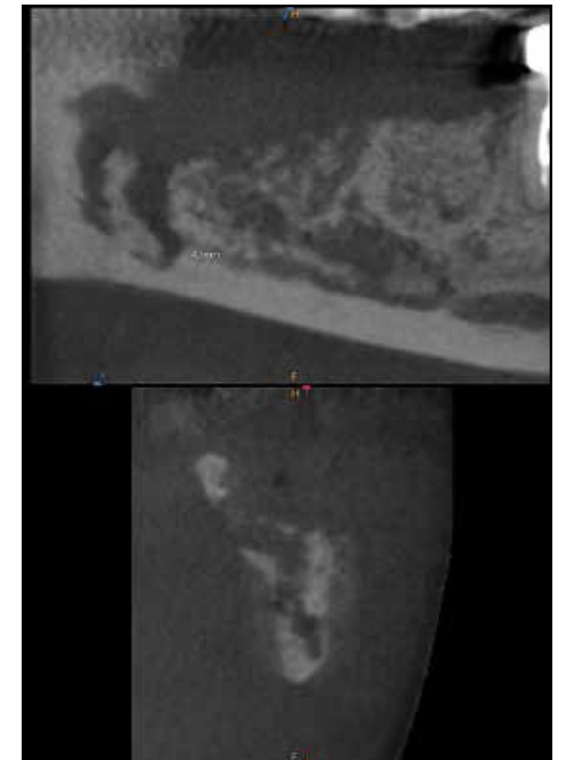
Dramatic infection-related osteolytic changes noted on CBCT
